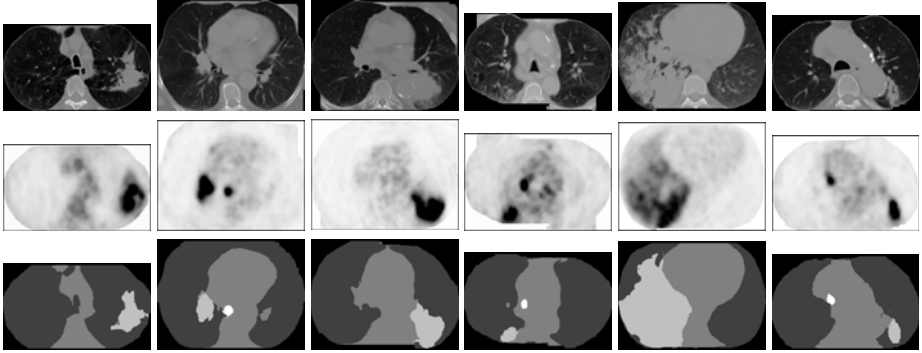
Six examples of structure localization, showing one transaxial slice pair per case. The top row is the CT image slice (after preprocessing); the middle row is the co-registered PET slice; and the bottom row shows the localization results, with 5 different gray scale values (black to white) indicating background, L, M, T and N.
